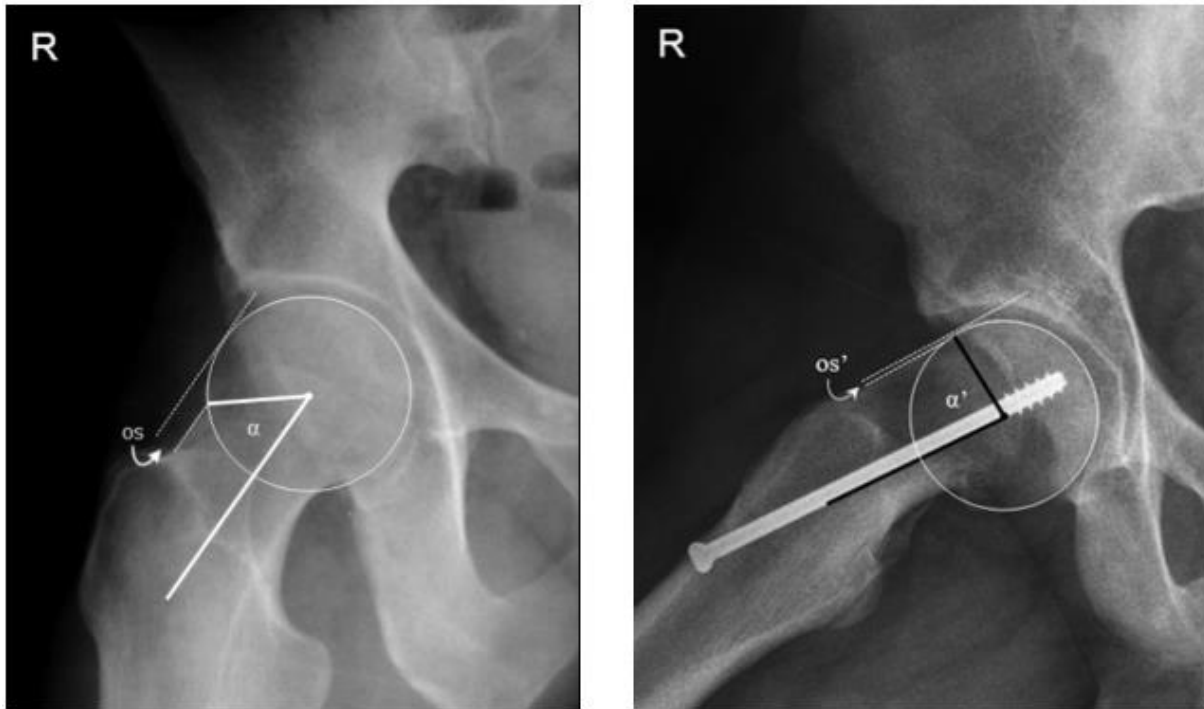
Left Image: right frog-leg radiograph of a patient with normal anterior femoral head-neck junction (OS) and alpha angle (α). Right Image: right frog-leg radiograph of a cam-type FAI patient with a small anterior femoral head-neck offset (OS') and large alpha angle (α'). (Image from [9])
